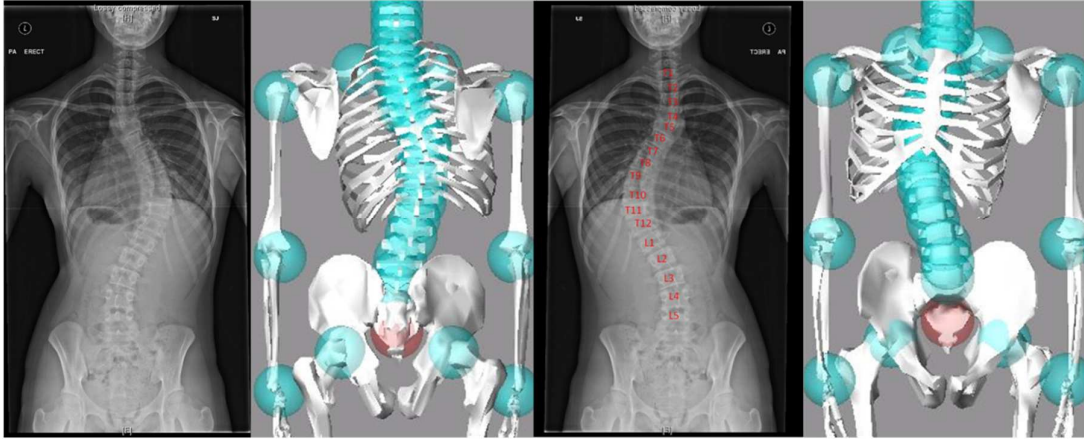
Front and back view of X-ray images and 3D model of PT1 in erect posture
